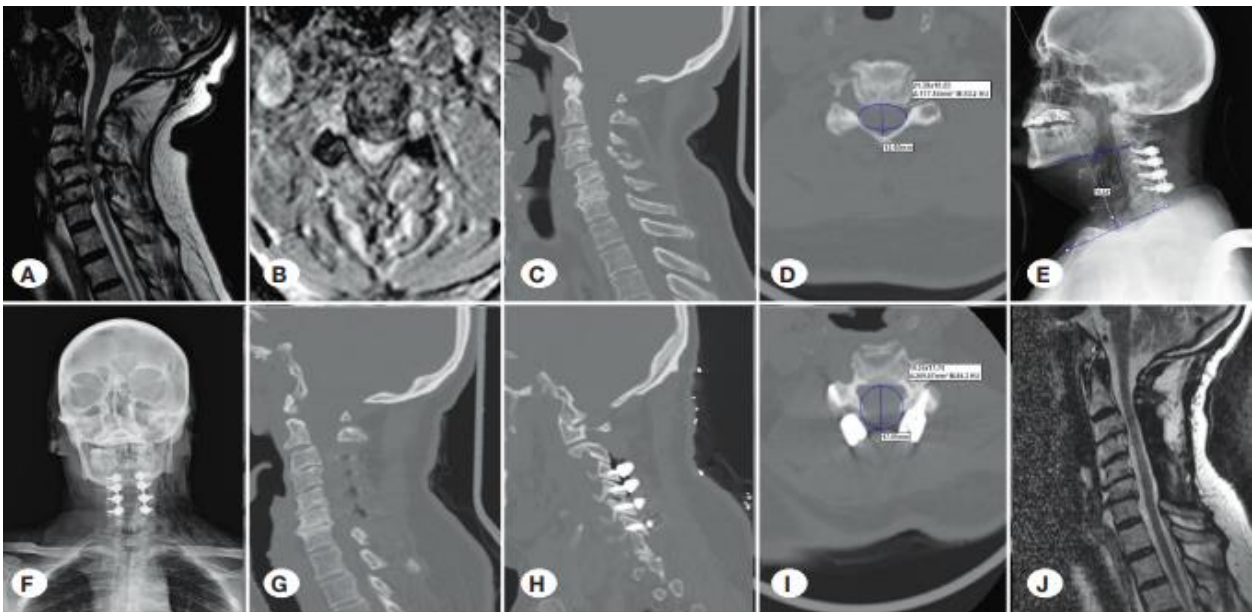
T2W MRI, preoperative (A) MRI, sagittal; (B) MRI, axial; (C) CT, sagittal; (D) CT, axial; (E) postoperative radiograph, lateral; (F) postoperative radiograph, anteroposterior; (G) CT, sagittal; (H) CT, sagittal; (I) CT, axial and (J) C3-C6 LF
